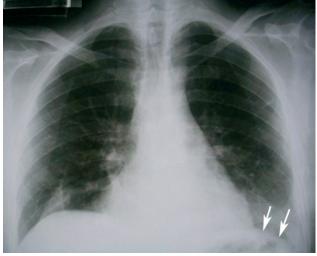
Conventional chest X-ray 30 days after the repair of diaphragmatic defect due to left Bochdalek hernia (arrows – normal position of the left diaphragmatic cupola).
